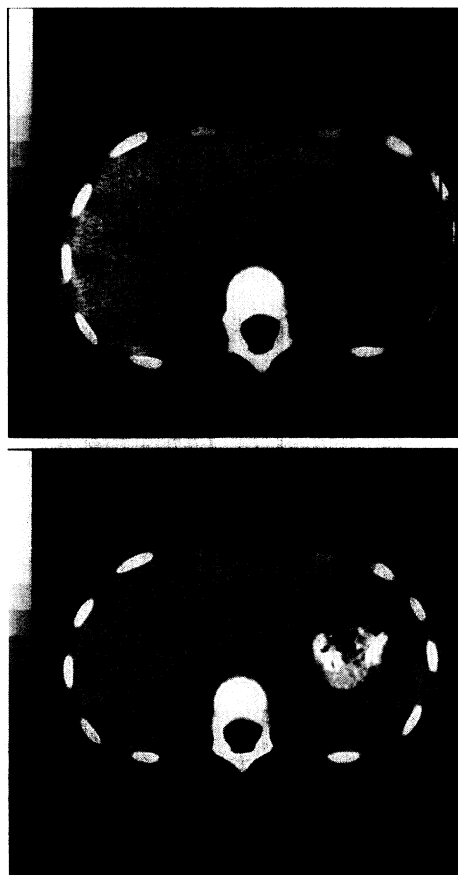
CT of adrenal glands. Top panel shows initial CT obtained several weeks after presentation. Adrenal glands are enlarged. Bottom panel shows repeat CT 2 months later showing resolution of the bilateral adrenal hemorrhages.
